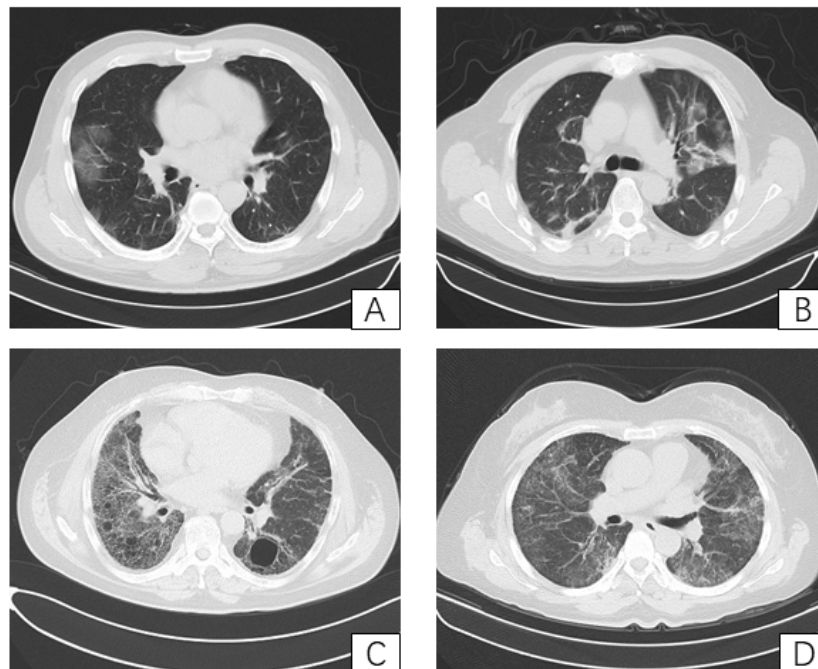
Chest CT findings of patients with COVID-19 and interstitial pneumonia. (A) A 33-year-old female diagnosed with COVID-19 on the 5th day after symptom onset; (B) A 41-year-old male diagnosed with COVID-19 on the 10th day after symptom onset; (C) A 65-year-old male diagnosed with NSIP based on chest CT findings at 2 and 5 weeks after symptom onset; (D) A 48-year-old female diagnosed with NSIP of unknown etiology after experiencing shortness of breath for 3 weeks.
